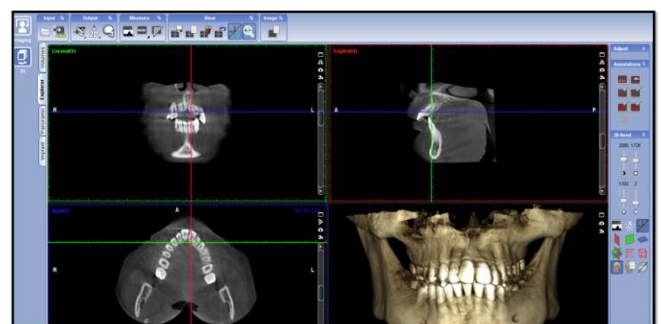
Data source was CBCT high volumetric data through CBCT Planmeca Romexis TM Software 2.3.1.R (Helsinki, Finland).
